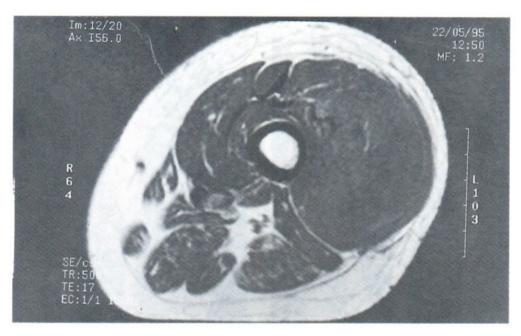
(a) Axial T1-weighted image of the left thigh showing a hypointense lesion in the left vastus lateralis
